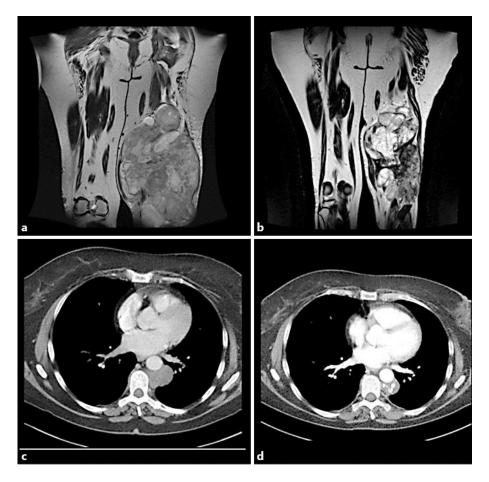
Change in tumor pattern. MRI before chemotherapy (a), MRI after chemotherapy (b), CT scan before chemotherapy (c) and CT scan after chemotherapy (d).
